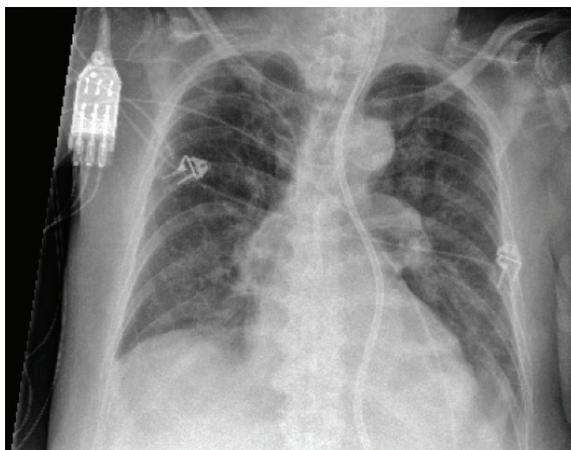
Image of same patient acquired on a different day. A grid was used, and X-ray dose was increased by a factor of 1.6.
